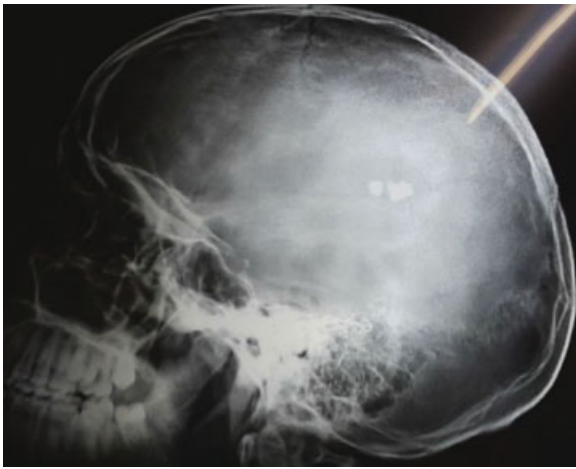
X-ray skull—lateral view shows double radio-opaque shadows in the parietal area, which were mistaken for overlapping of the broken bones in the depressed skull fracture.
